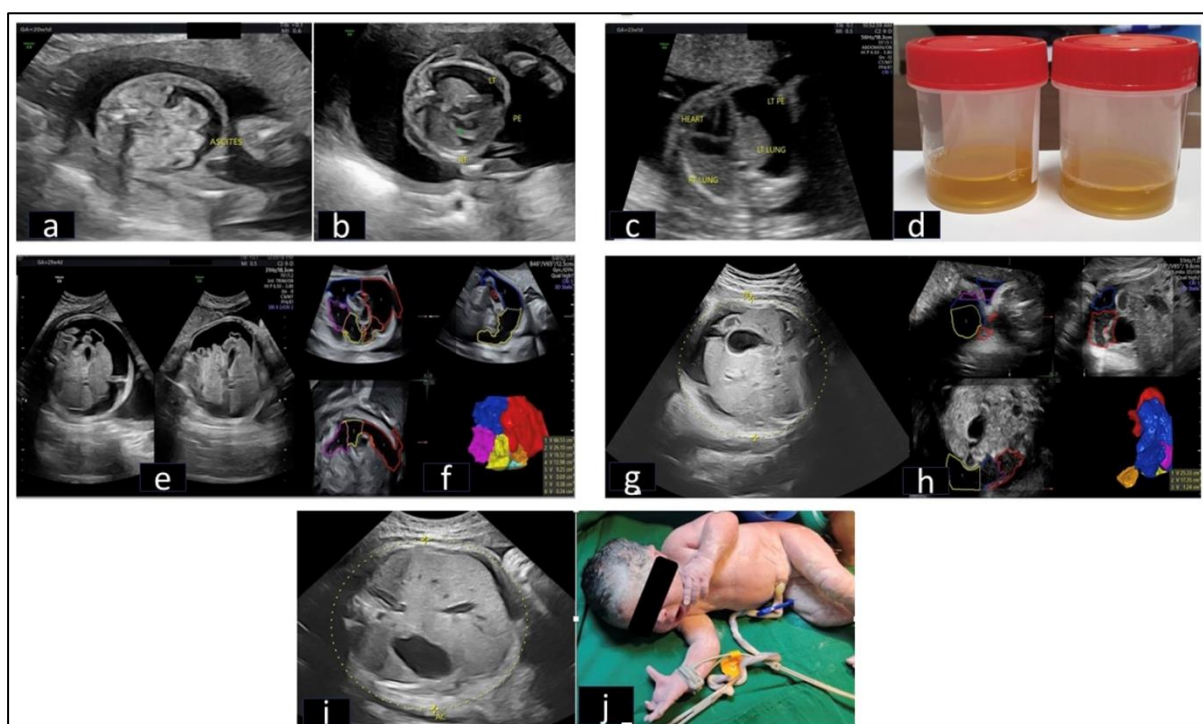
Ultrasonography findings at different gestational ages (a) Mild fetal ascites and (b) mild bilateral fetal pleural effusion (left>right) at 20 weeks of gestation. (c) Transverse section of the fetal thorax showing severe pleural effusion at 23 weeks and a right shift of the heart. Left lung compressed by the effusion. Antenatal thoracocentesis is performed to facilitate lung development. (d) Straw-coloured chylous pleural fluid after thoracocentesis. (e) Transverse section of the abdomen showing gross fetal ascites at 29+5 weeks. (f) The volume of Fetal ascites on 3D ultrasonography is ~132 ccs. (g) Transverse section of the abdomen showing mild ascites and no pleural effusion at 32 weeks gestation (h) Volume of Fetal ascites on 3D ultrasonography ~40 ccs. (i) Transverse section of the abdomen showing minimal residual ascites and no pleural effusion at 35.5 weeks gestation (j) Newborn at 36 weeks with no gross abnormality and APGAR 8/9 at 1 and 5 minutes.
